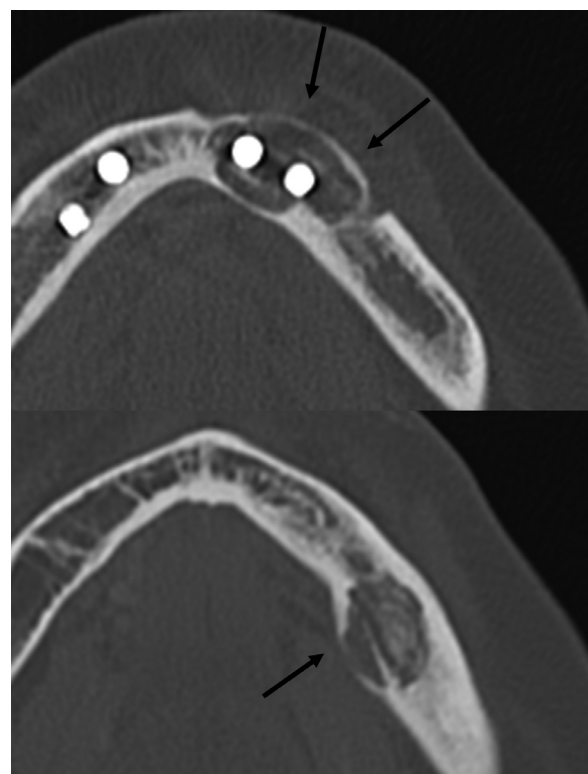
Axial computed tomography (CT) bone window image demonstrates sequestrum formation within an expansive lytic lesion involving the left body of the mandible.
